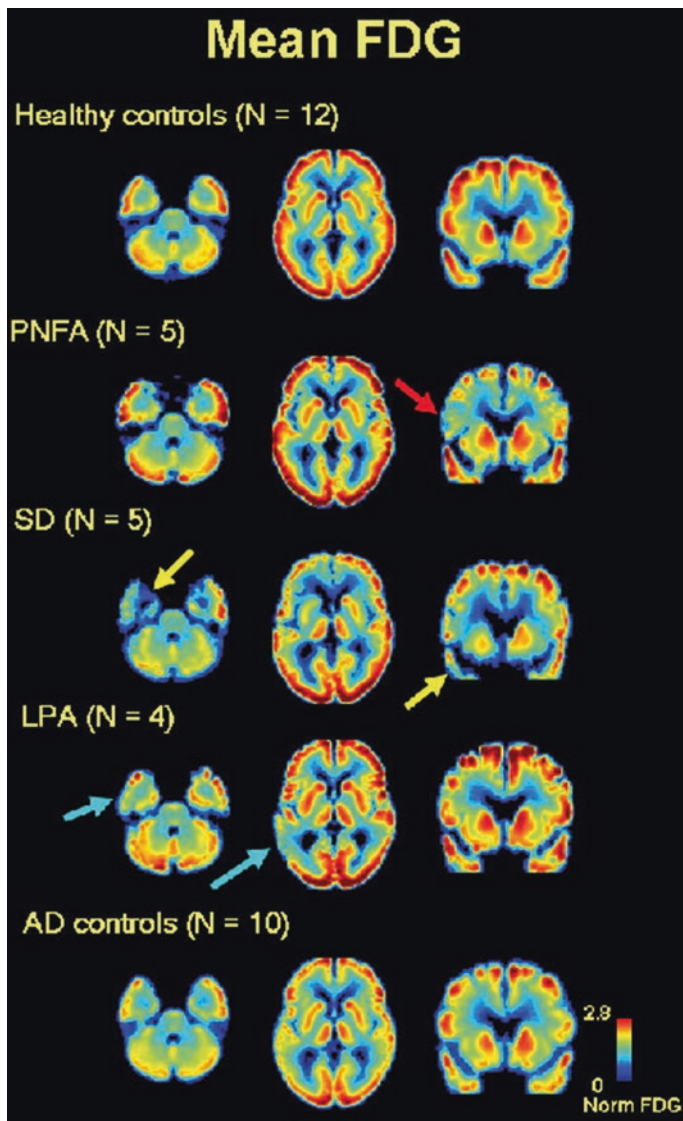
[¹⁸F]-FDG-PET in different types of FDG patterns. Axial ($z = 9, z = 27$) and coronal ($y = 64$) slices of mean atrophy-corrected FDG images from (top to bottom) normal controls ($N = 12$), PNFA ($N = 5$), SD ($N = 5$), LPA ($N = 4$) and AD ($N = 10$). PNFA is characterized by left frontal hypometabolism (red arrow), SD by left greater than right anterior temporal hypometabolism (yellow arrows) and LPA by asymmetric left temporoparietal hypometabolism (light blue arrows)
